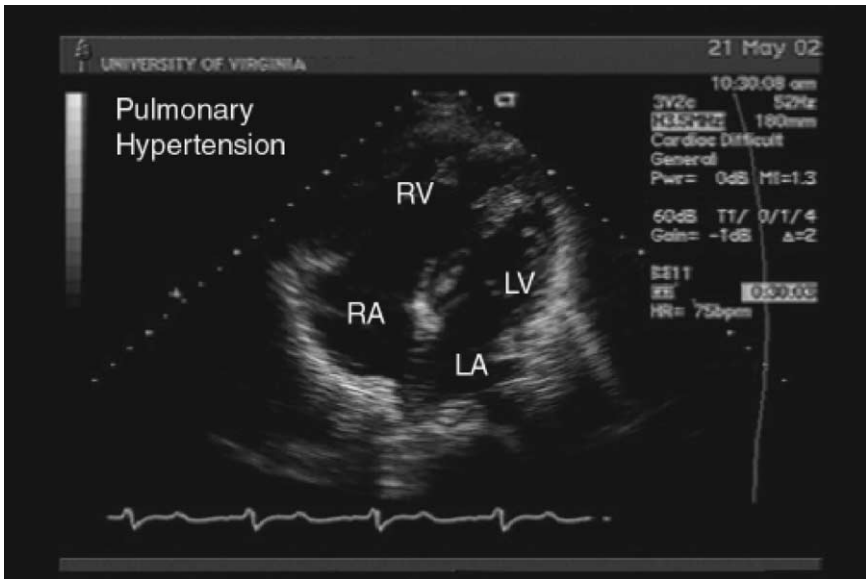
Two-dimensional apical echocardiogram of a patient with severe pulmonary hypertension and RV enlargement from an ASD. The heart is displayed upside-down by convention, and the massively enlarged RV dwarfs the smaller left ventricle (LV). This patient's RV dysfunction could lead to a reduction in pulmonary artery pressure caused by reduced cardiac output, despite severely elevated pulmonary vascular resistance.
